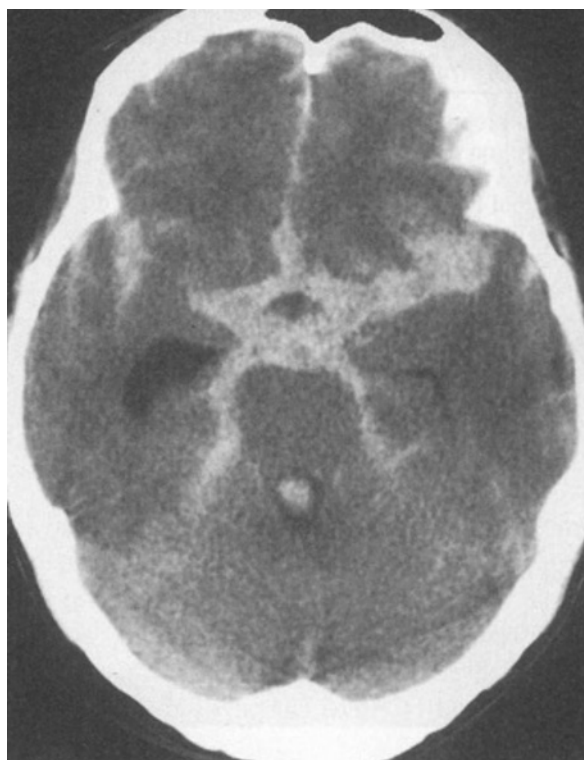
Subarachnoid haemorrhage on computed tomography scan of the head.
